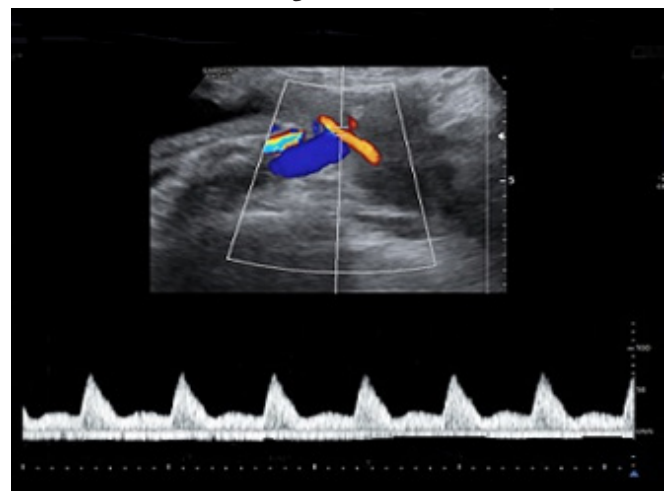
Uterine artery Doppler sonography. Doppler sonography of the crossing of the uterine artery with the iliac artery in transabdominal ultrasonography and uterine artery wave pattern
